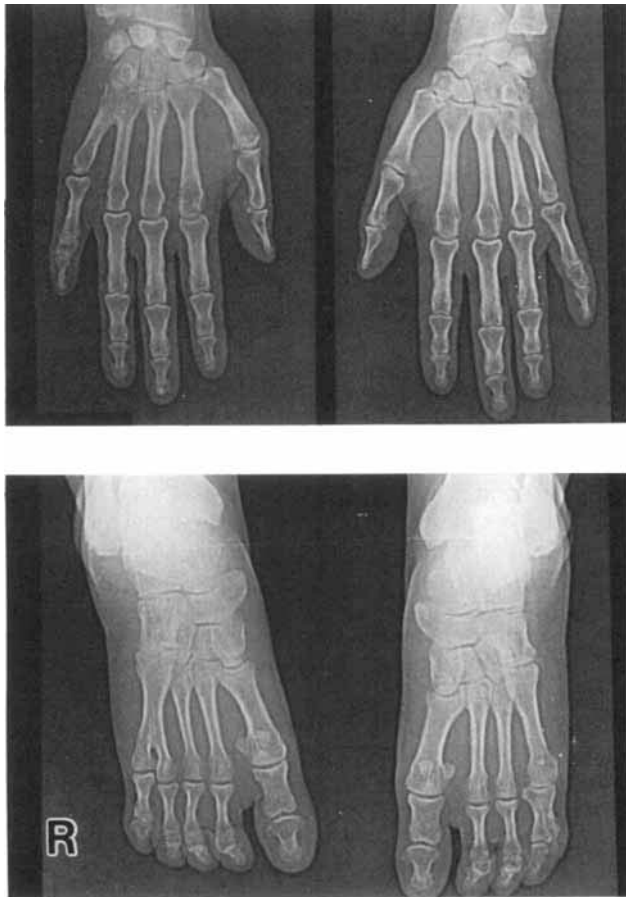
X-ray photography of the hands (upper) and the foot (lower) of the present case. Bilateral fifth middle phalanx are short. The left fifth metatarsal bone is absent, and the fifth metatarsal bone and the proximal bone are thick. Extrusion of bone is recognized. The syndactyly of the right fourth and the fifth metatarsal bone at base and at body is shown.
